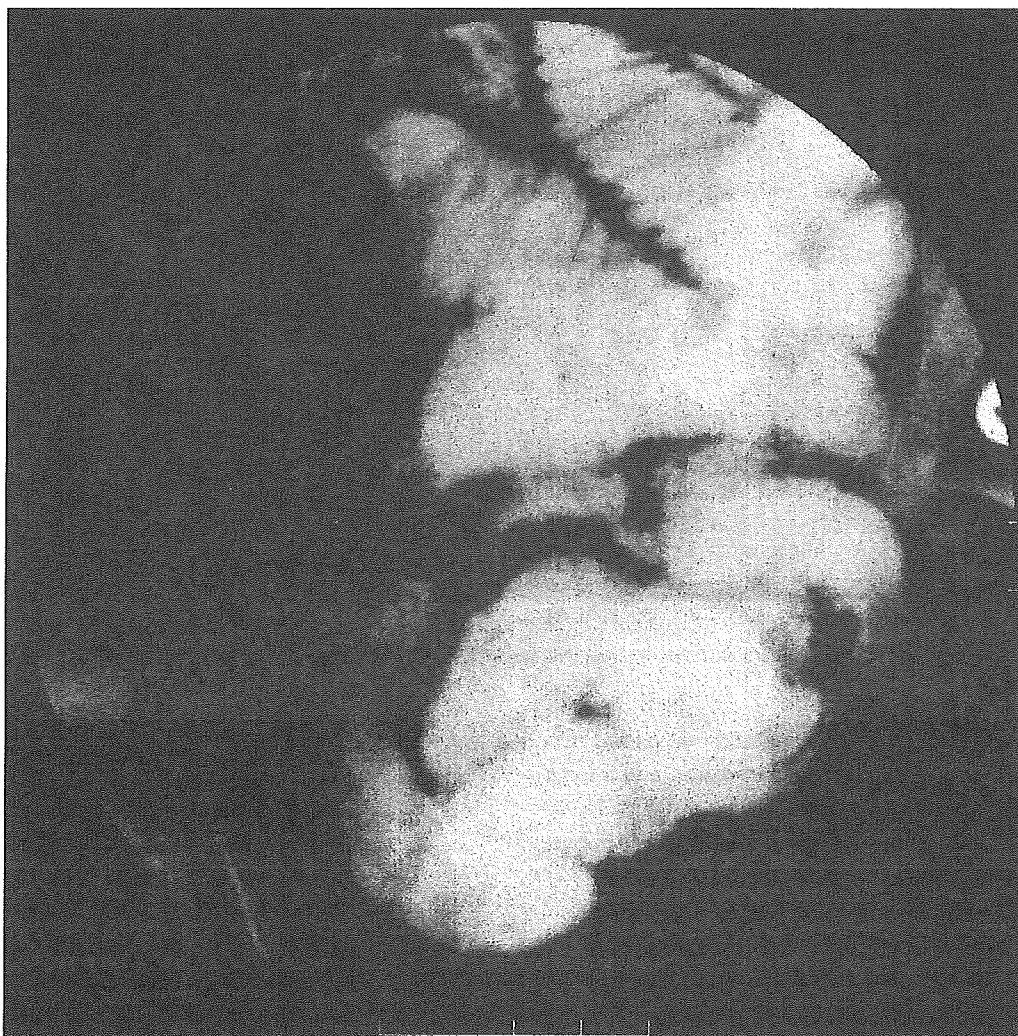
Abdominal radiograph after intraduodenal injection of amidotrizoic acid (Gastrografin; Nihon Shering)
